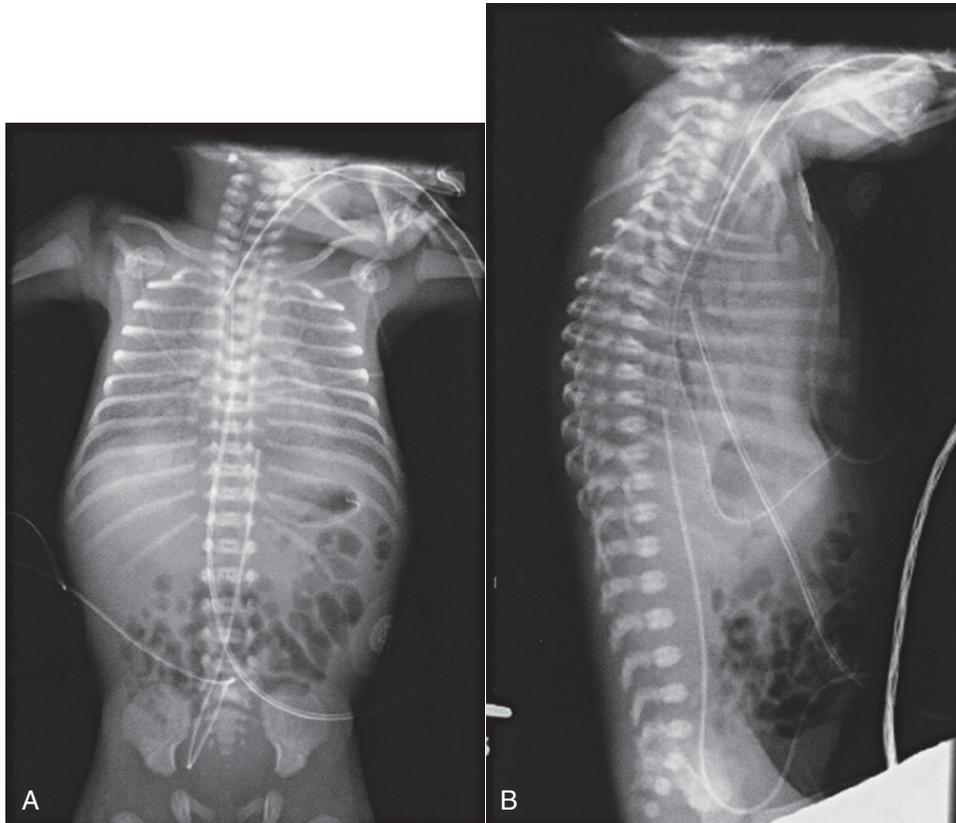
Radiopaque appearance of severe respiratory distress syndrome. Anteroposterior (A) and lateral (B) radiographs show diffuse hazy appearance with low lung volumes and air bronchograms that extend into the periphery.
